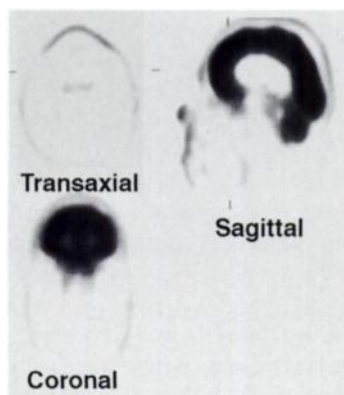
FDG-PET scan in a 66-yr-old man with persistent hoarseness and edematous larynx but negative biopsies for malignancy. The patient was instructed to remain silent for 30 min after FDG injection. Little glucose activity is seen in the tongue or other organs.
